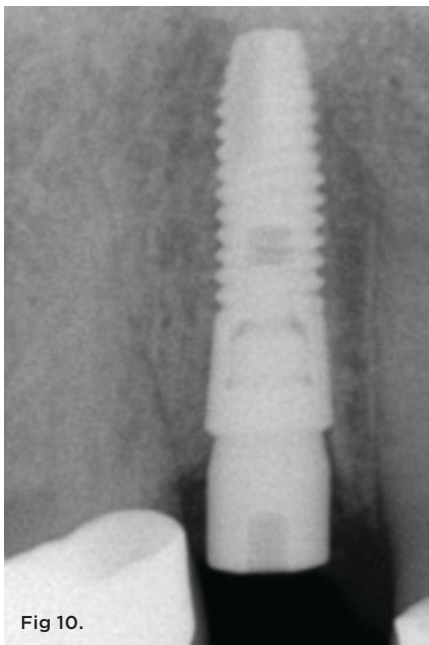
Radiograph taken immediately after surgery. Implant position is evaluated in relation to the adjacent teeth and proximal bone levels. Fig 11. Vacuum-formed template fabricated on the working cast of the patient prior to the fracture of the crown on tooth No. 6. This will be used with the model obtained from the surgical impression to form a screw-retained temporary crown on the bench top, rather than intraorally. Fig 12. Bisacryl provisional material (Luxatemp® Ultra) is flowed into the perforated vacuum-formed template after fixation of a temporary abutment to the implant replica. Fig 13. The first postoperative appointment, approximately 10 days after surgery. Loose sutures are removed and the area gently debrided/polished. Minimal inflammation is present and a wide band of keratinized mucosa exists. Fig 14 and Fig 15. The scanbody (ATLANTIS™ IO FLO) in place to facilitate a digital impression.
